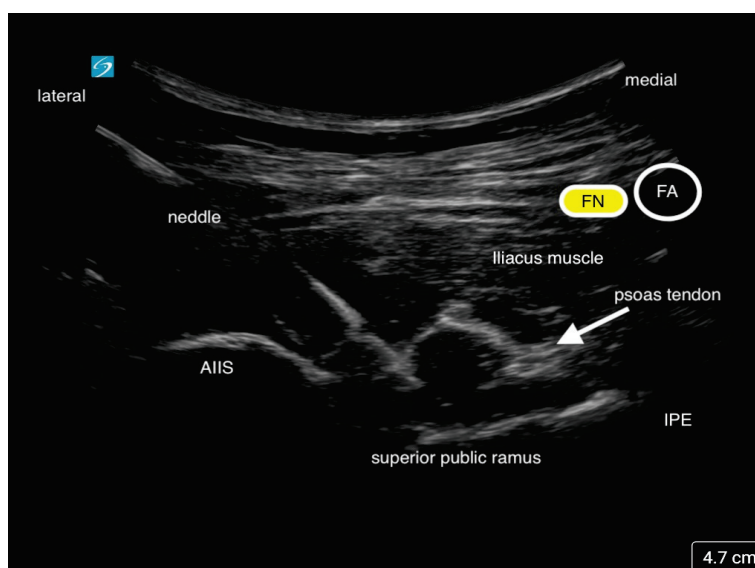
This is an ultrasound image of the Pericapsular Nerve Group Block (PENG). Local anesthetic is injected below the psoas tendon. The needle approach is from lateral to medial. The femoral nerve (FN) and femoral artery (FA) is seen medially.
